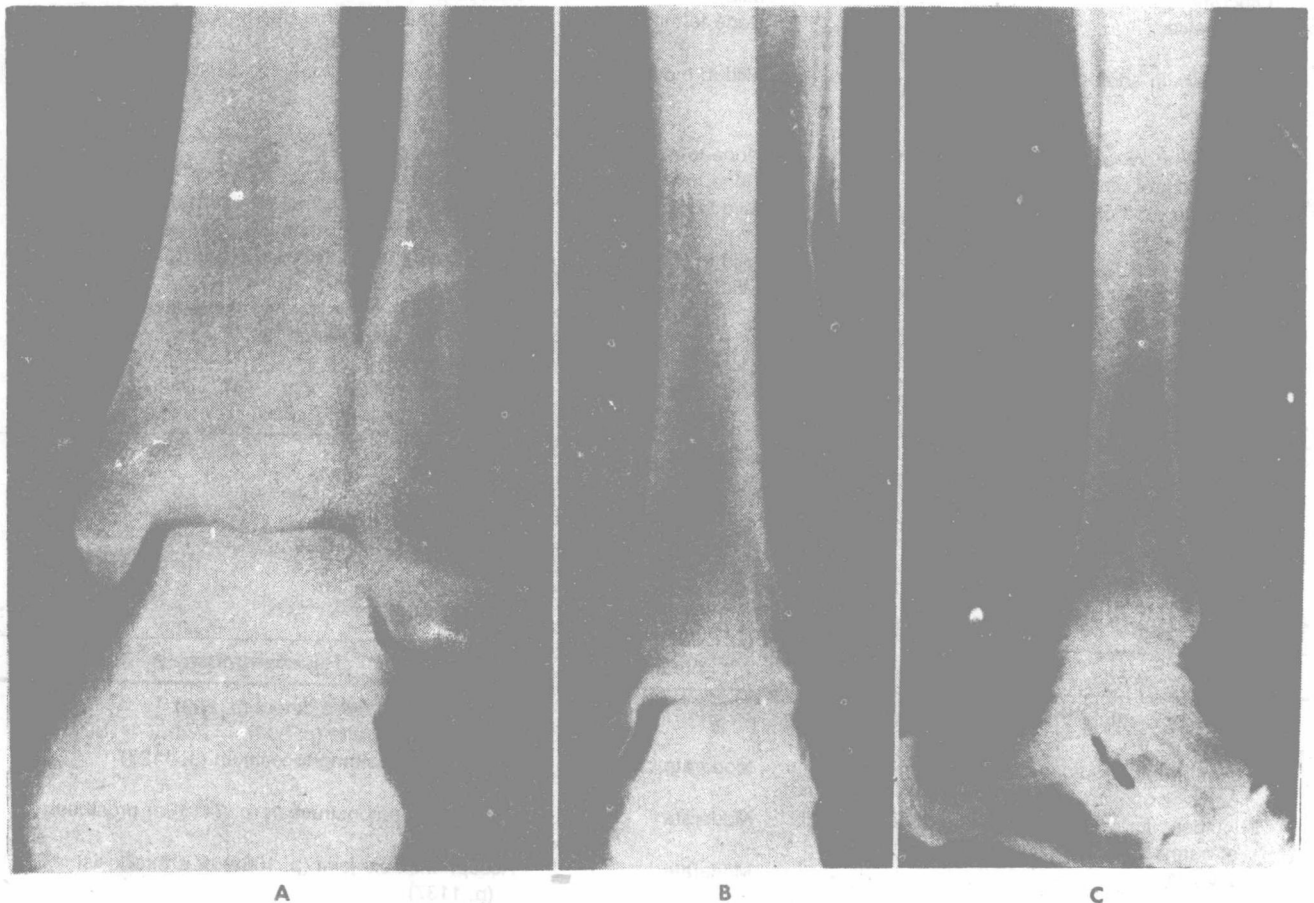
Long follow-up (39 years) of patient with resection of distal fibula for osteogenic sarcoma. No recurrence, deformity, instability, or metastasis occurred. A, Preoperative roentgenogram. B and C, Anteroposterior and lateral roentgenograms 39 years later.
